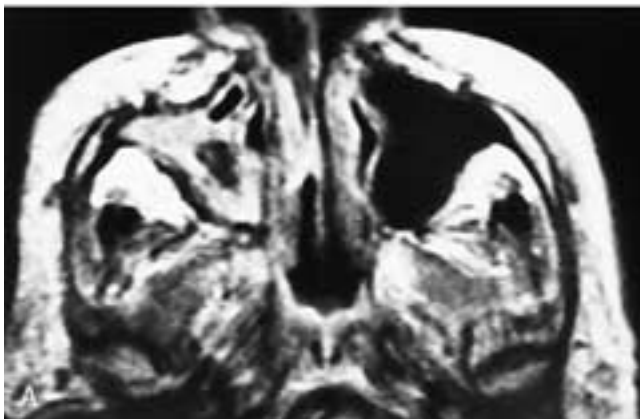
Axial proton density (A) and T2-weighted (B) images show inflammatory-type mucosal thickening in the right maxillary sinus. In the center of the sinus is an ovoid mass with low signal intensity. This is an aspergilloma with surrounding inflammation. This patient had aspergillosis.
